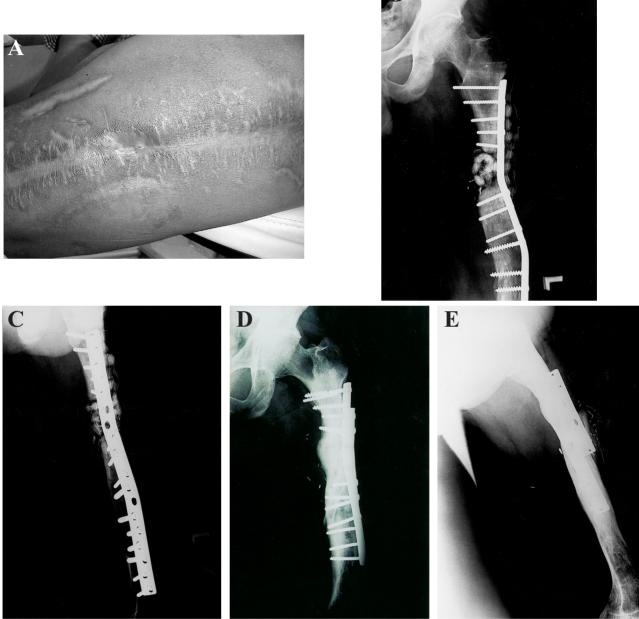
Case 5 (A) Photograph of the thigh of a 46-year-old male showing a discharge sinus over the lateral aspect of the thigh. (B,C) Radiographs of the femur showing internal fixation and local antibiotic beads for infected nonunion of femoral shaft fracture. (D,E) Bone grafting and 30 sessions of hyperbaric oxygen therapy were performed to promote bone union. At 30 months of follow-up, no recurrence of infection was noted and the fracture was united.
